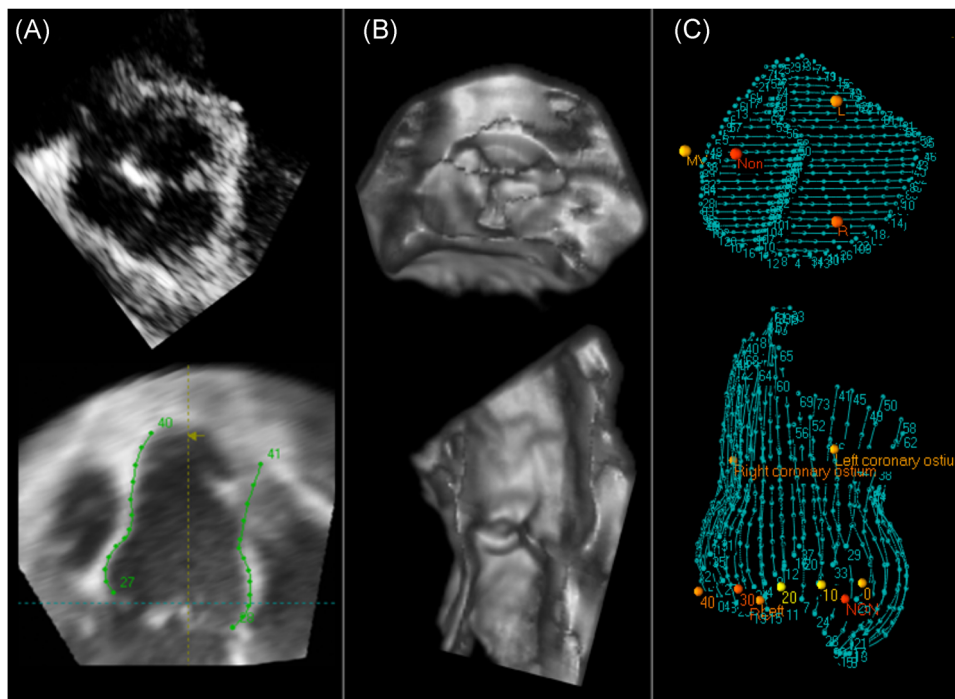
Comparison of aortic valve and root imaging techniques. A, Two-dimensional echocardiography short-axis view of the aortic valve cusps (top) and long-axis view of the aortic root (bottom). B, Raw three-dimensional echocardiography short (top) and long-axis views (bottom) of the aortic valve and root before image processing demonstrating the limited quantitative utility of 3D images alone. C, Three-dimensional reconstructed datasets demonstrating high resolution modeling of a bicuspid aortic valve and aortic root in the short (top) and long-axis views (bottom). L, left (coronary cusp); MV, mitral valve; Non, noncoronary cusp; R, right (coronary cusp)
